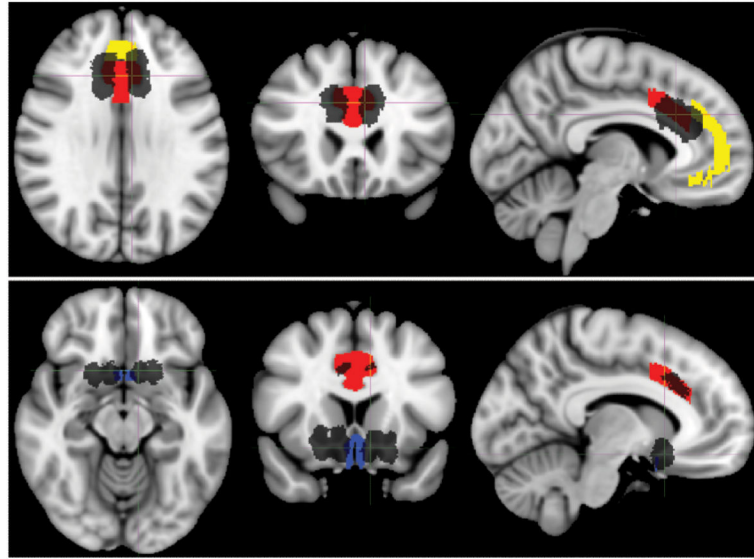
Representative lesion mask projected on coronal T1-weighted Montreal Neurological Institute (MNI) MNI152 template, Johns Hopkins University (JHU) white-matter tractography atlas, and Center for Morphometric Analysis (CMA) structural atlas. Lesion masks are shown in black, and each color represents a unique atlas region of interest. Upper: Anterior cingulotomy. Lower: Limbic leucotomy.
